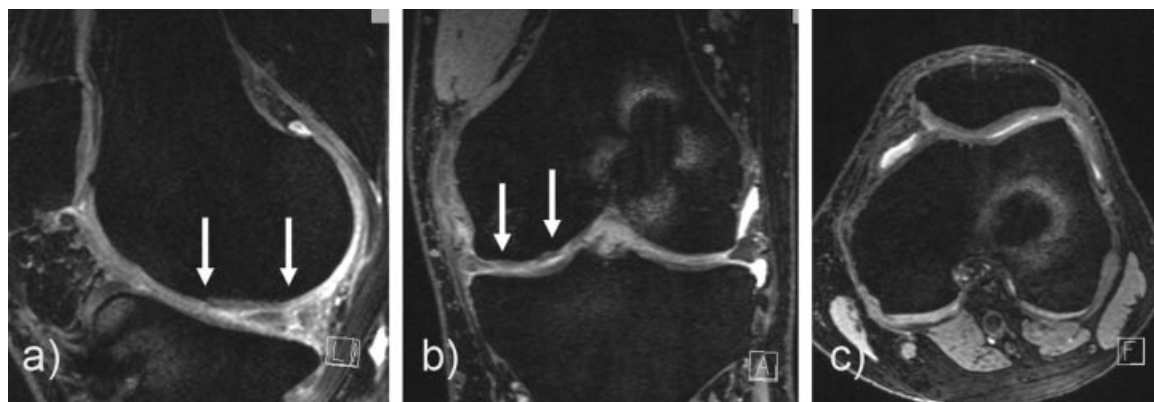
Morphological, isotropic, 3D double-echo, steady state (DESS) sequence from one patient 3 months after MACT surgery (baseline MRI). Multiplanar reconstruction of sagittal (a), coronal (b), and axial (c) plane; arrows mark the area of cartilage repair.
